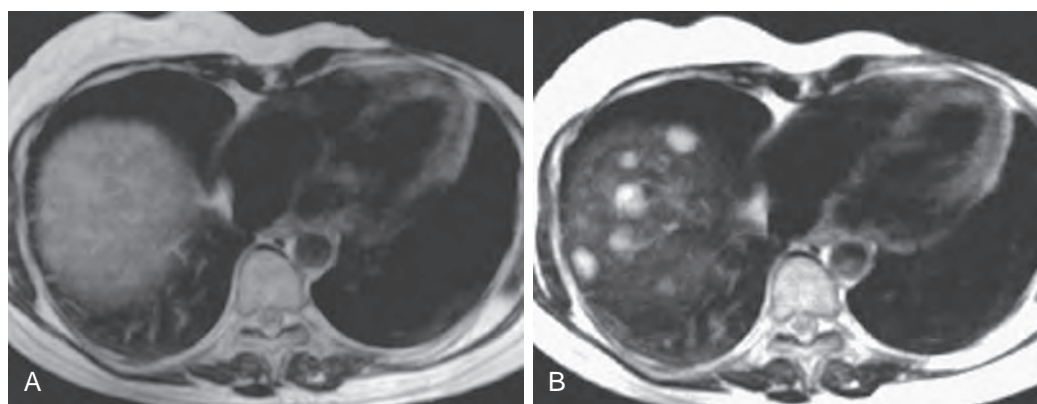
MRI of liver metastases with SPIO-enhanced scan. Metastases that are barely visualized on T2-weighted MR image (A) can be easily detected after the administration of SPIO (B). (Courtesy Dr. Tomoaki Ichikawa, Yamanashi University, Yamanashi, Japan.)
